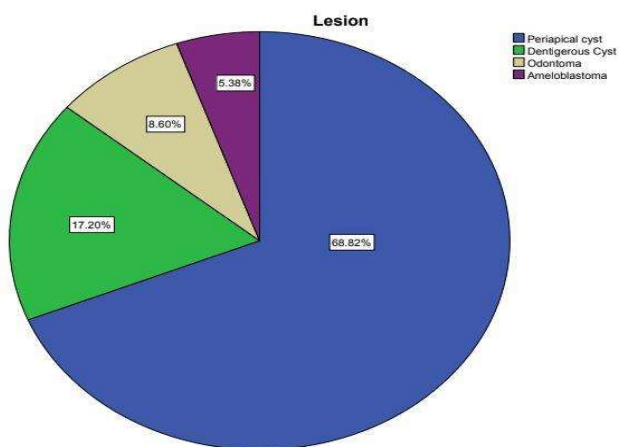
Pie chart representing the most common unilocular radiolucency. 68.82% of the patients were diagnosed with periapical cyst (Blue), 17.20% of the patients were diagnosed with dentigerous cyst (Green), 8.06% of the patients were diagnosed with odontoma (Beige) and 5.38% of the patients were diagnosed with ameloblastoma (Purple).
